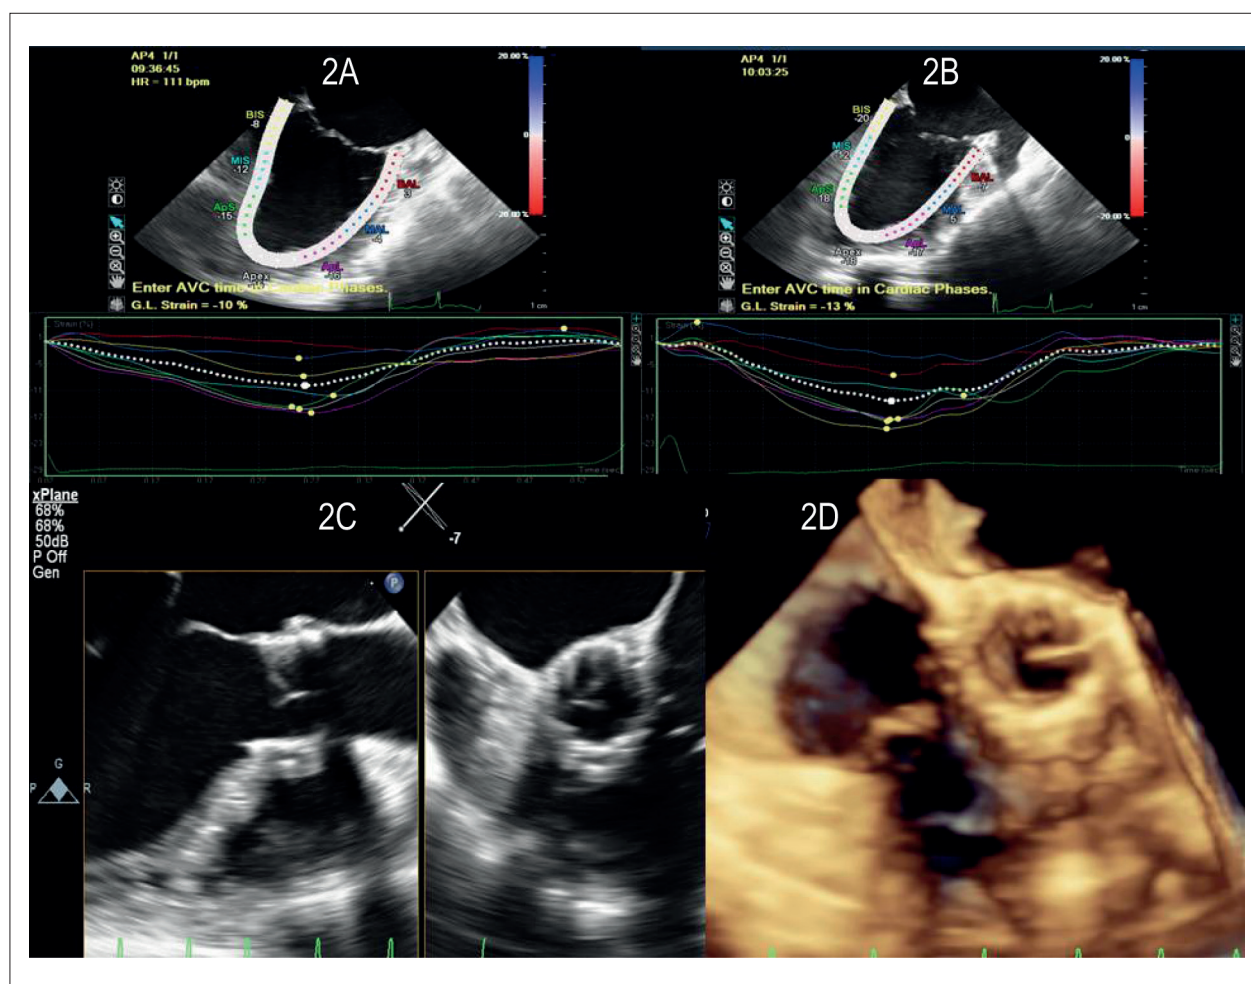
Myocardial strain analysis before (Figure 2A: -10%) and after (Figure 2B: -13%) percutaneous implantation of aortic prosthesis. Figure 2C: demonstration with two-dimensional transesophageal echocardiography of implanted aortic prosthesis, left figure (longitudinal plane), right figure (transverse plane). Figure 2D: demonstration with three-dimensional transesophageal echocardiography of the implanted aortic prosthesis, en face. Case 4 patient.
